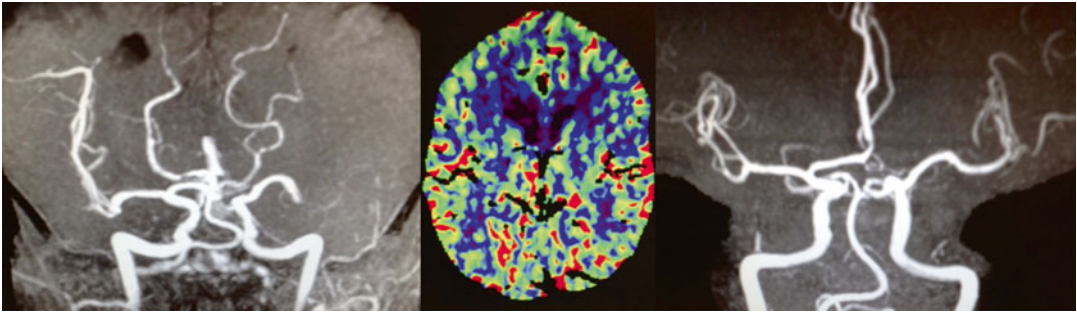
Acute left MCA occlusion (*left*) successfully treated with IV tPA as shown by CT perfusion (*middle*) and the MRA (*right*) obtained within 3 h of treatment with tPA
